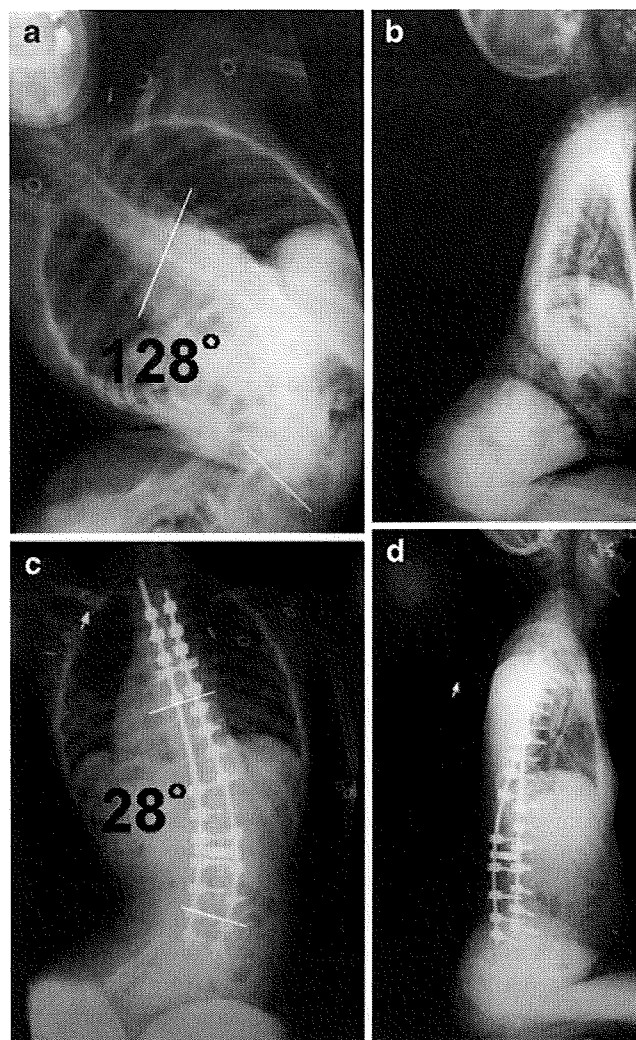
Preoperative sitting radiographs of a 12-year-old boy with Duchenne muscular dystrophy (DMD). Anteroposterior radiograph shows a severe scoliosis of 128° . FVC at six weeks before operation was 19% and FVC increased to 22% the day before operation. C and D Surgical correction of scoliosis was performed successfully. Successful extubation was performed on the operative day. Postoperative sitting views show significant coronal correction of 28° (78%). At six weeks after operation, FVC remained stable at 22%
